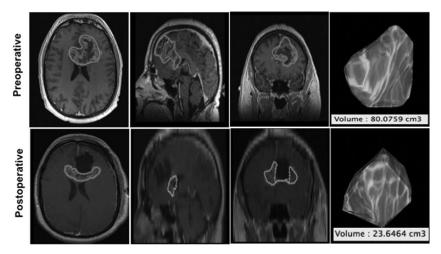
Volumetric measurements. The pre- and postoperative MRIs were obtained and reviewed for each patient. All patients underwent axial MRI with gadolinium at 1.5- to 3-mm intervals on the day prior to or on the day of surgery and within 48 h of surgery. Using OsiriX software, the area of contrast enhancement was measured for each axial section, and tumor volume was quantified based on the sum of axial areas in a semiautomated manner.
